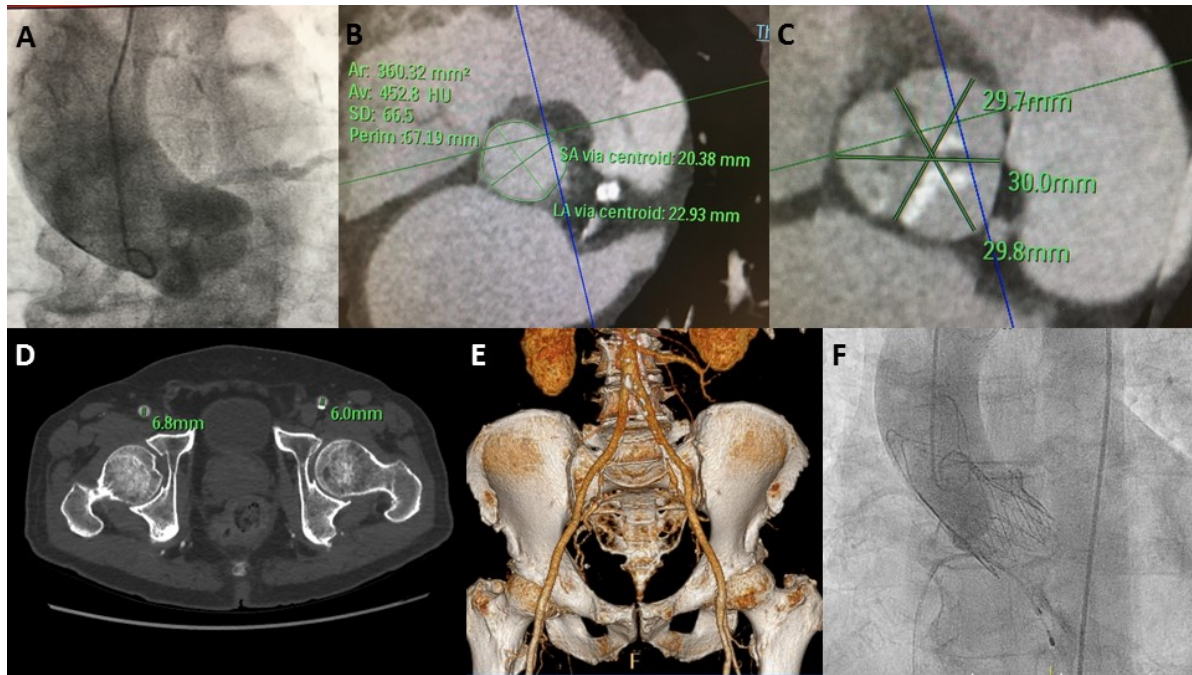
Typical characteristics of a female patient with severe aortic stenosis. A. Aortogram showing the three cusps projection which is usually used for valve implantation. B. Computerized tomography image showing the measurement of an aortic annulus. This measurement shows an area of 360 mm² and a perimeter of 67 m which is consistent with small annulus. C. Computerized tomography image showing the measurement of the sinus of Valsalva. The measurement is consistent with narrow sinus. D. Computerized tomography image from a common femoral artery It shows a moderate caliber of the artery enough for transfemoral access. E. Computerized tomography image showing 3D reconstruction of a non-tortuose iliofemoral axis. F. X-ray image showing the final aortogram after valve implantation showing a good result
